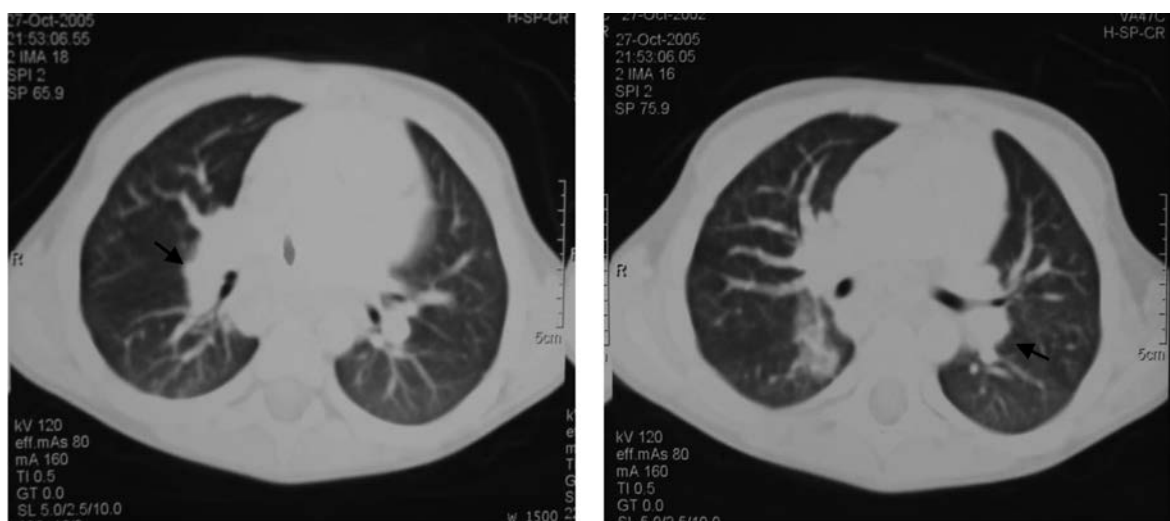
CT of the thorax with paratracheal conglomerated lymph nodes.
